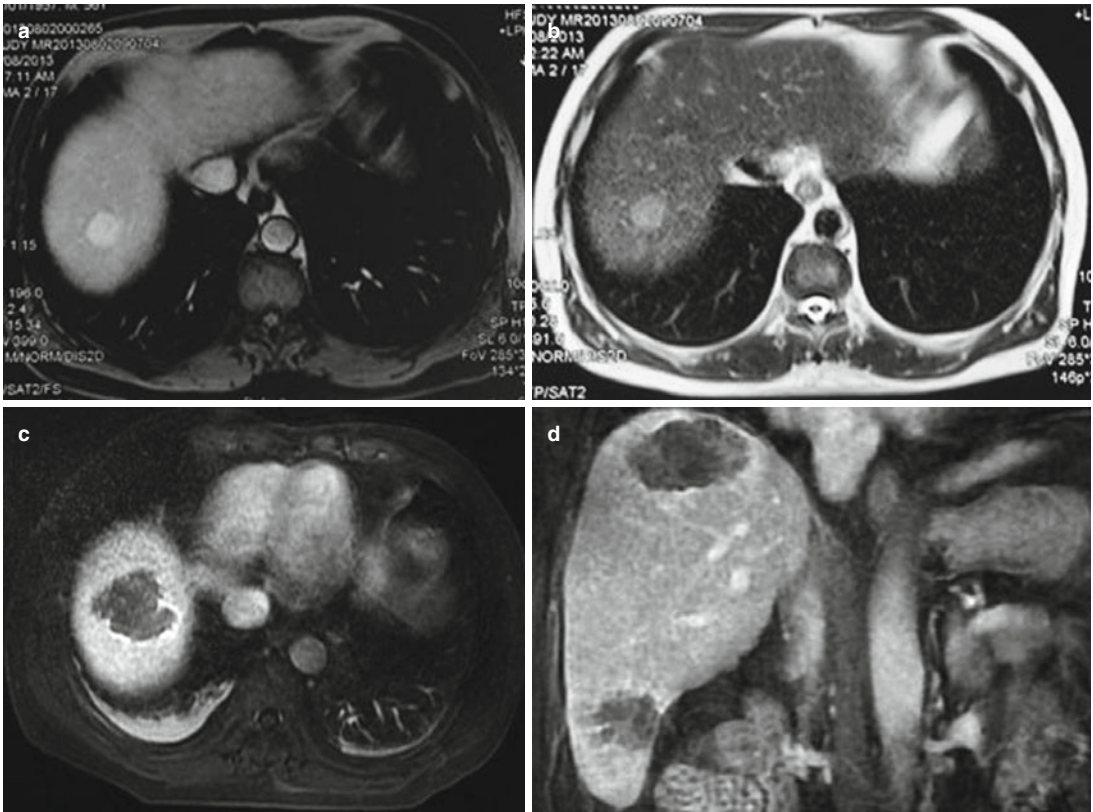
Contrast-enhanced MRI in a 56-year-old man who underwent MWA of HCC. (a) Hepatic delay phase preablation image shows an HCC (*arrow*); (b) hepatic T2 preablation image shows an HCC (*arrow*) with the size of 2.0×1.8 cm; (c) hepatic transverse
